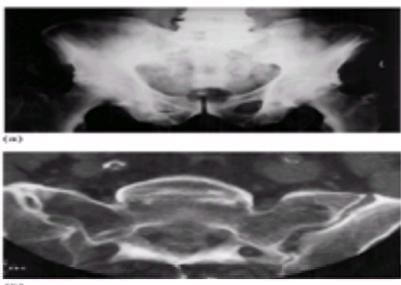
Diffuse idiopathic skeletal hyperostosis. (a) There is new bone formation on the iliac crest and, in particular, superiorly at the sacroiliac joints, giving an impression of fusion across these. (b) CT scan to show new bone formation anteriorly across the sacroiliac joints in another patient with DISH. There are no erosions.
